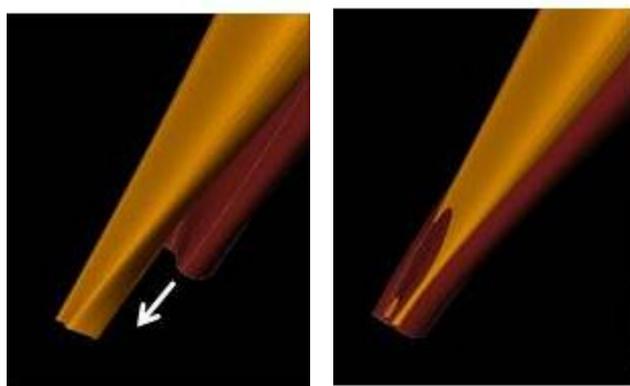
Optimization process matching muscle mechanics model (red) to MRI measured shape (in gold).
